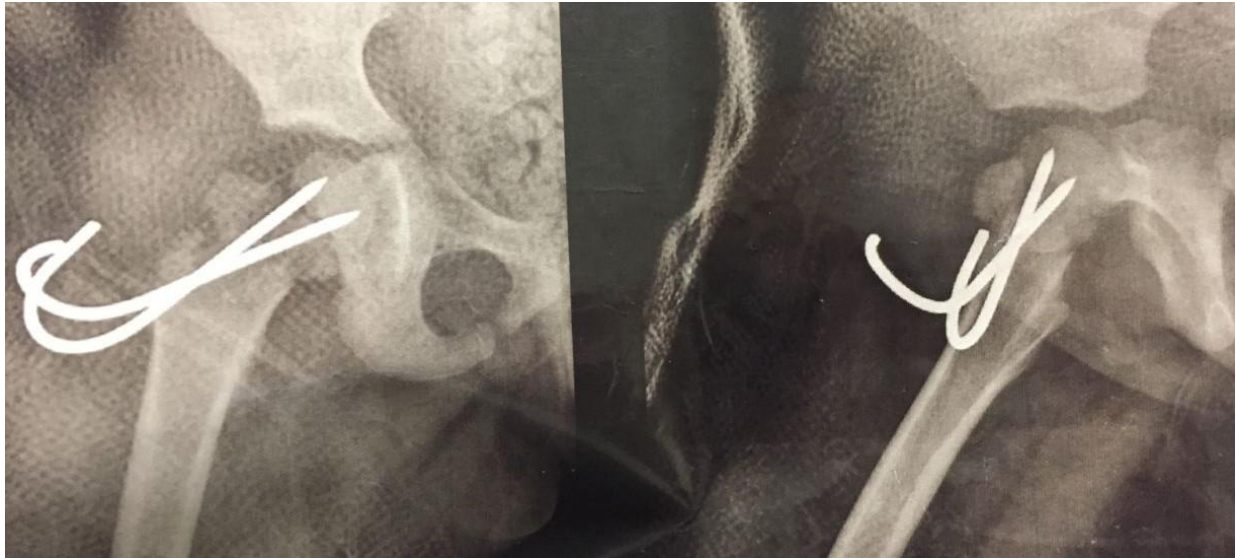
10 day post-op radiograph.
